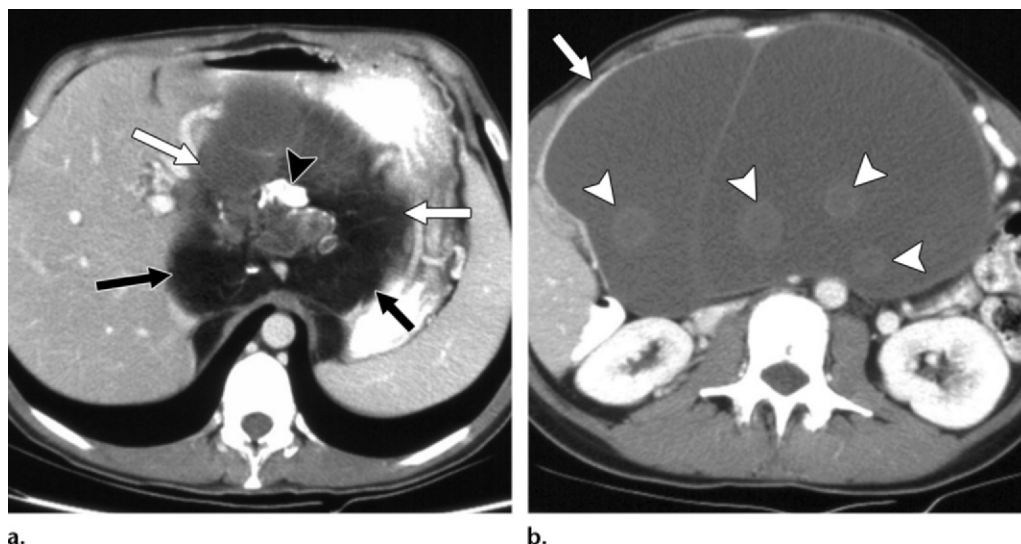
Mature cystic teratoma in a 17-year-old girl. Axial contrast-enhanced discontinuous CT images of the upper abdomen show a complex mass (white arrows) that contains fat (black arrows in a), calcifications (arrowhead in a), and soft-tissue-attenuation rounded structures (arrowheads in b).
